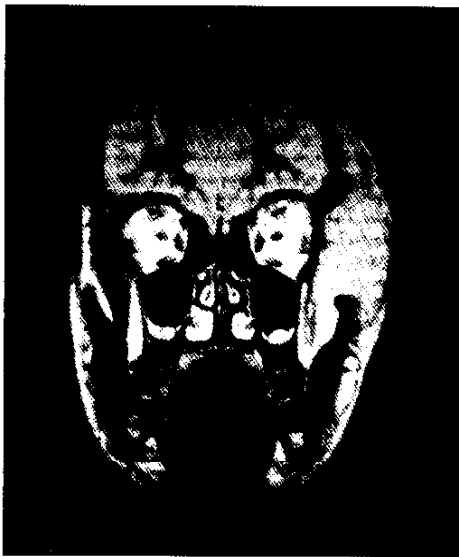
Coronal MRI showing face soft tissue haemangiomas in a 6 year-old boy
